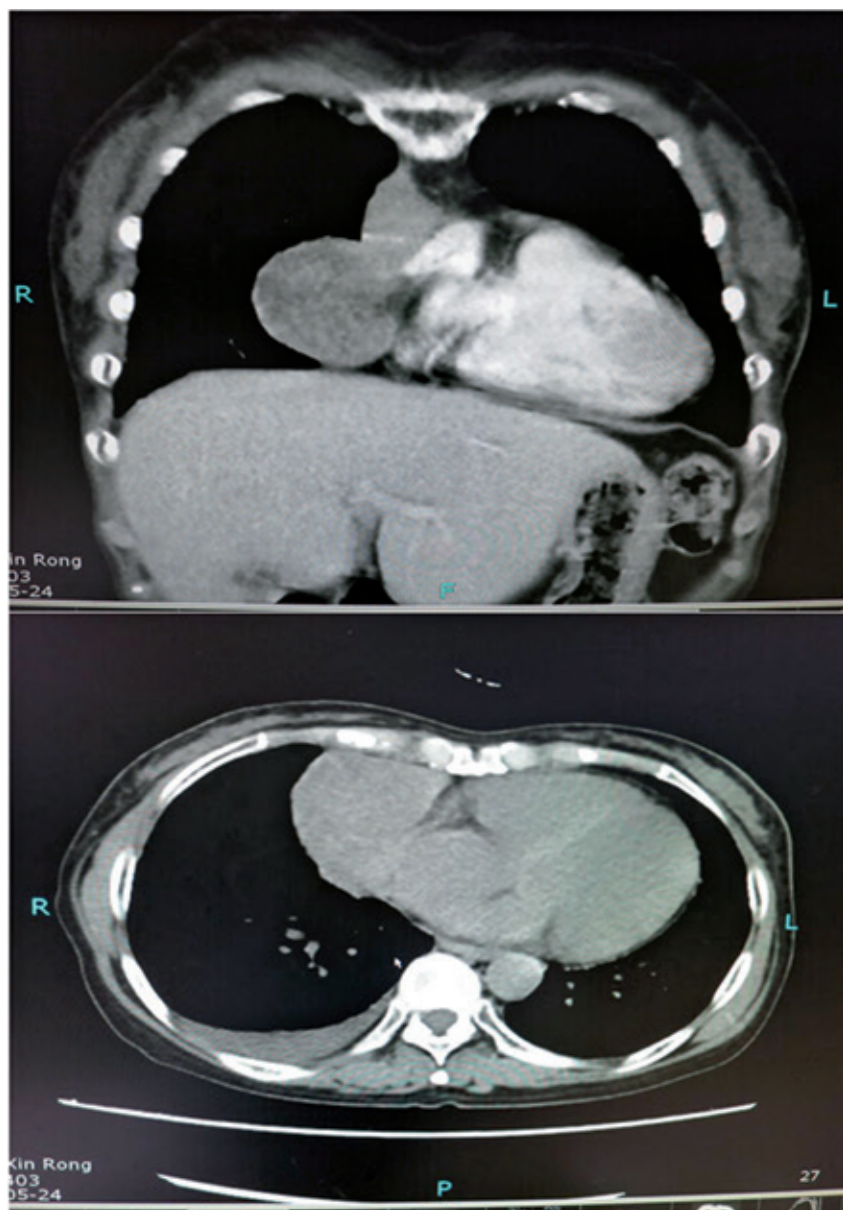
Computed tomography of the chest showing a mass in the anterior mediastinum (case 1)
